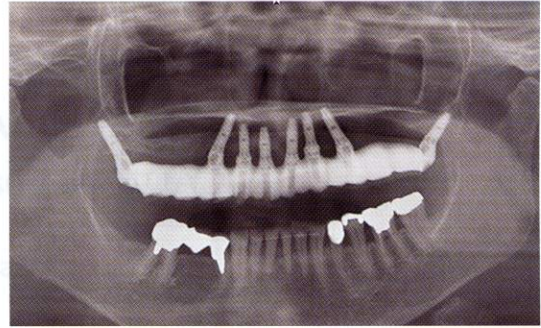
Panoramic X-ray photo after installation of final prosthesis
